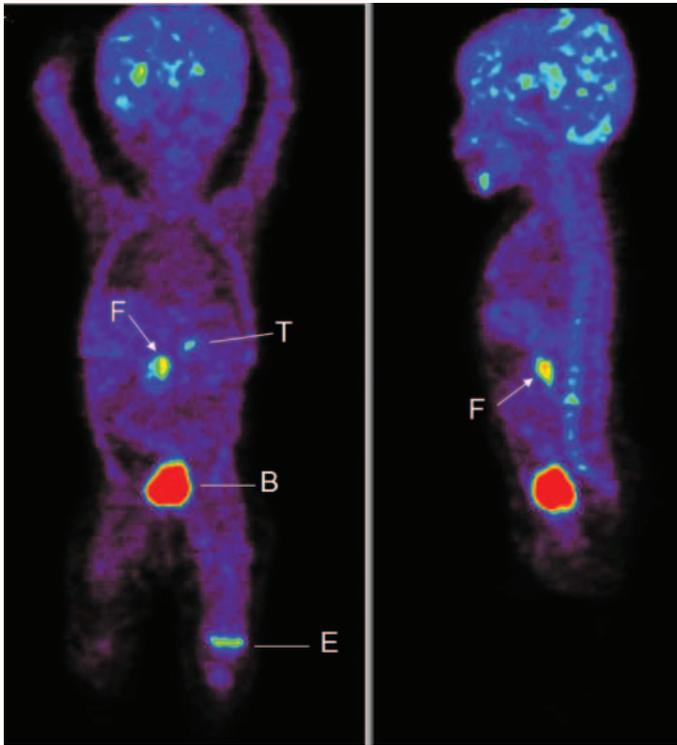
Whole-body tracer distribution of [¹⁸F]-DOPA depicted in coronal and sagittal views of a patient with focal CHI (patient 1). The hyperinsulinemic focus with a maximum tracer SUV of 4.0 in the medial aspect of the pancreatic head (f) is shown with a white arrow. Despite the continuous flushing with saline, the bladder (b) is well visualized. Other areas with positive tracer uptake and indicated with white lines are the pancreatic tail with maximum SUV of 2.6 (t) and the epiphyseal plate (e) of the left distal femur. Note also the moderate uptake in the bone marrow behind the focus seen in the sagittal view.
